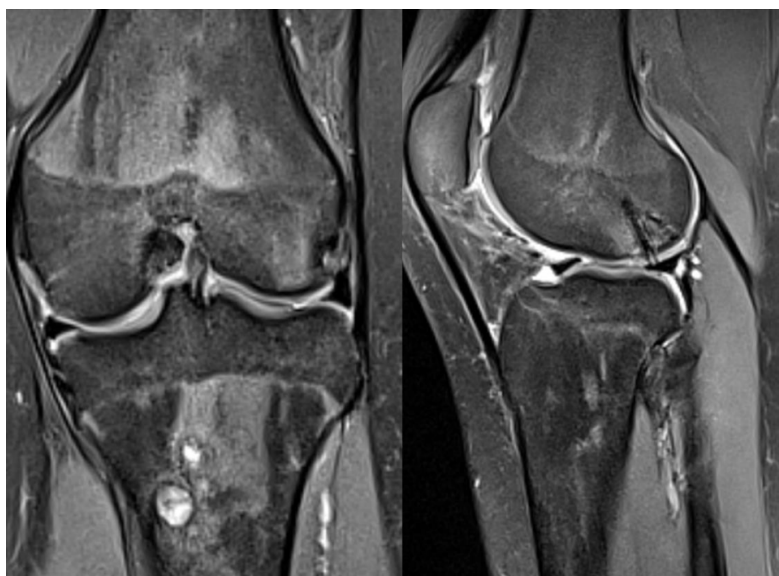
MRI images revealing lateral condyle edema and displaced injury
